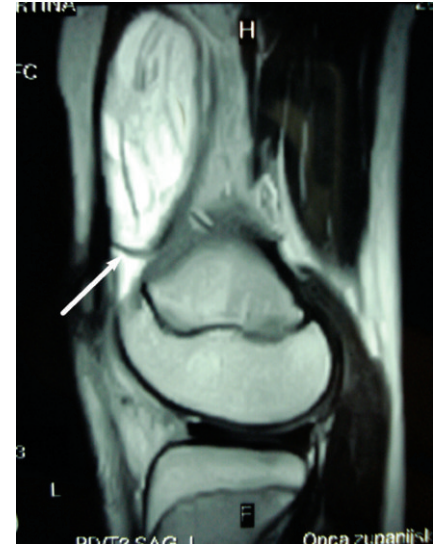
Sagittal magnetic resonance image of knee showing suprapatellar cyst between quadriceps tendon and femur with intact suprapatellar septum (arrow).
